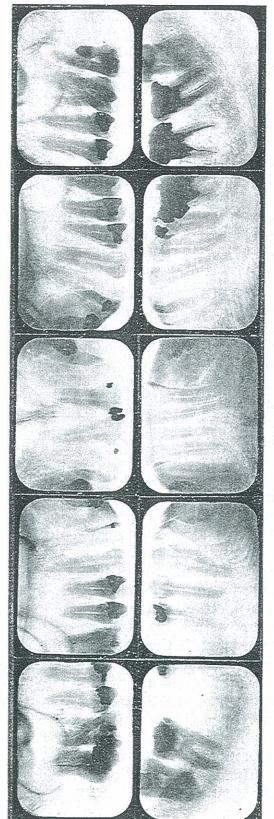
ROENTGENOGRAPHIC APPEARANCE OF TEETH OF CASE 1273 WITH EXTREME SLEEPINESS.
